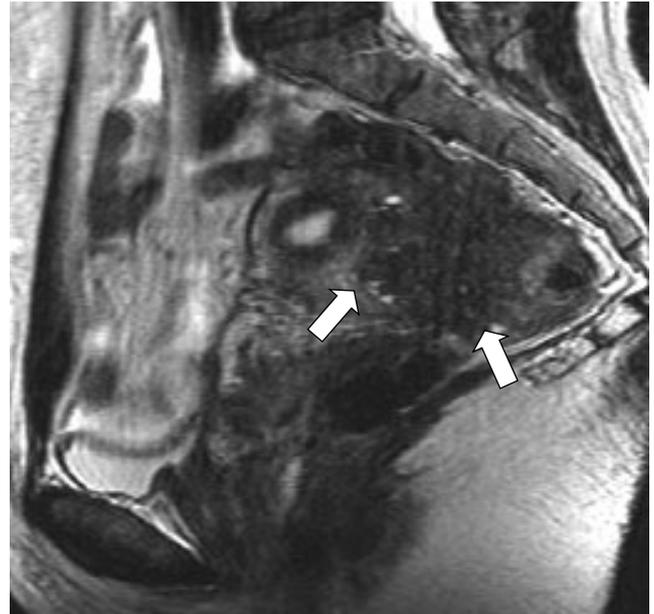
Magnetic resonance image (sagittal image, T2-weighted sequence) showing a huge hypointense endometriotic nodule, with hyperintense hemorrhagic foci, located within the rectovaginal wall (arrows) and infiltrating the rectal wall. Hypointensity of the lesion is invading the isointensity of the normal rectal wall (same patient as Figure 3).
